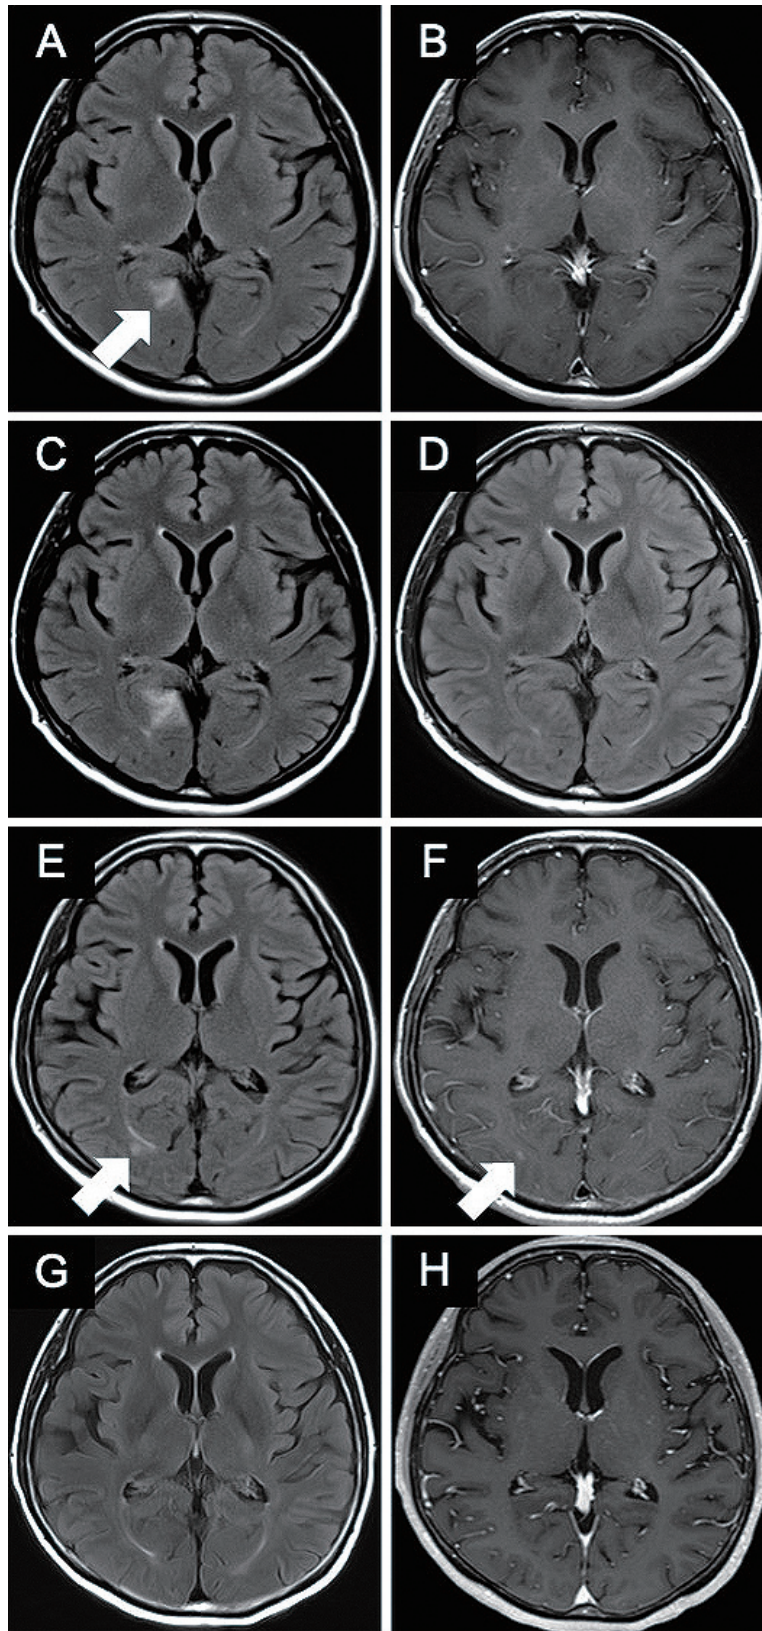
MRI of intracranial lesions. Fluid attenuated inversion recovery image revealed a high-signal lesion at the medial surface of the right occipital lobe (A), which was not contrast enhanced (B). Although the lesion expanded within 1 month (C), the patient achieved CR after chemotherapy (D). Another contrast-enhanced lesion in the right occipital lobe was detected in MRI (E and F). The patient achieved CR after chemotherapy (G and H). MRI, magnetic resonance imaging; CR, complete response
